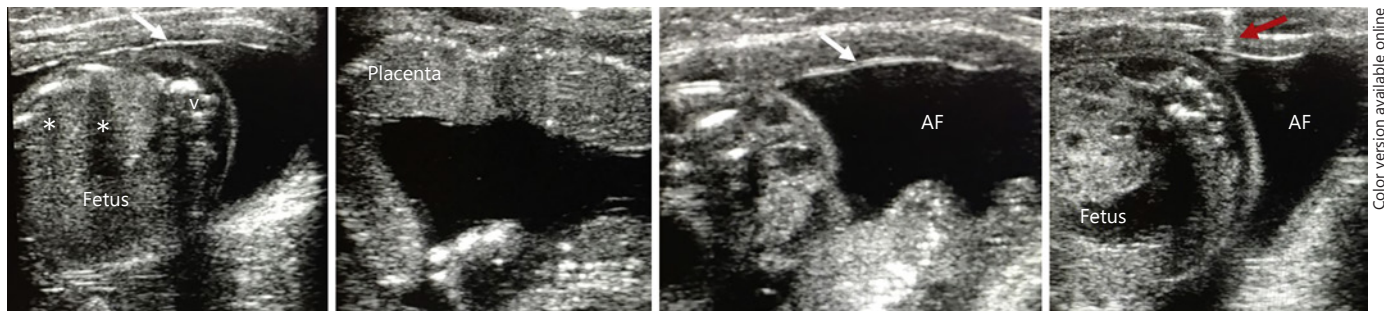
Ultrasound images 2 days after hysterotomy. The white arrows highlight intact membranes, the red arrow artifact from suture. AF, amniotic fluid; v, fetal vertebrae; *, fetal rib shadowing.
